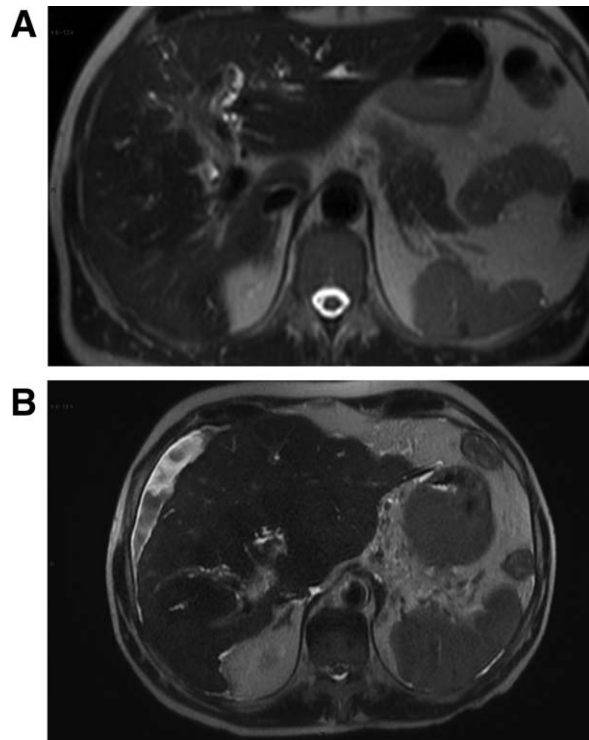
Radiologic natural disease course. Worsening disease: 41-year-old patient in 2005 (A) and 2010 (B). T2-weighted images showing worsening on dysmorphism, with increase in caudate-right lobe ratio, lobulation of the liver contours, atrophy of posterior right lobe, hypertrophy of medial left lobe. Signs of portal hypertension with portosystemic shunts, intraperitoneal fluid, and increase in spleen size on B.
